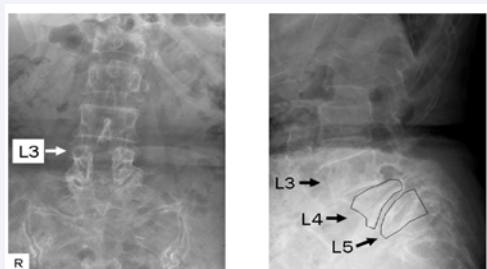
Plain X-ray films showing multi-level spondylolisthesis of L3-L4, L4-L5, and vertebral deformities of L4 and L5.
